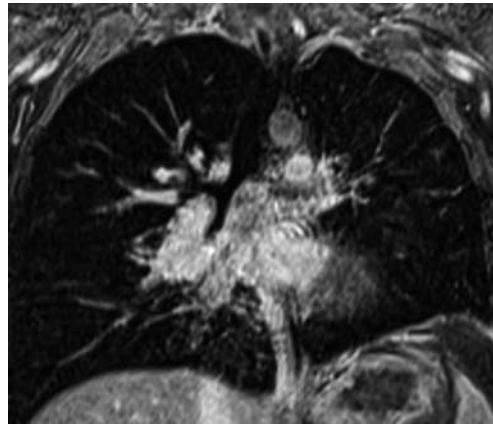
Transverse T1-weighted contrast-enhanced fat-suppressed image; abnormal left hilar mass narrowing the left pulmonary artery
